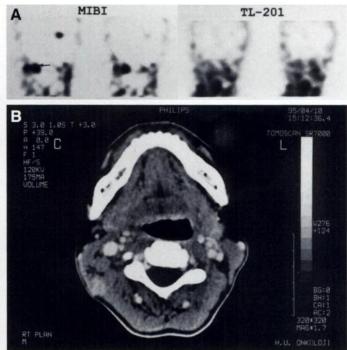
(A) Coronal slices of MIBI SPECT head and neck study demonstrate an area of increased focal uptake in the right superior cervical region consistent with lymph node metastasis, whereas coronal slices of <sup>201</sup>TI SPECT of the corresponding region do not show any discernible focus of abnormal radiotracer accumulation. Additionally, the other focus of radiotracer uptake superiorly in the left is consistent with the secretion of MIBI through the ventricles; right ventricle is not symmetrically visualized because of the patient's slightly tilted position. (B) CT study of the nasopharynx shows an enlarged lymph node (arrow) in the right upper cervical region consistent with lymph node metastasis.
